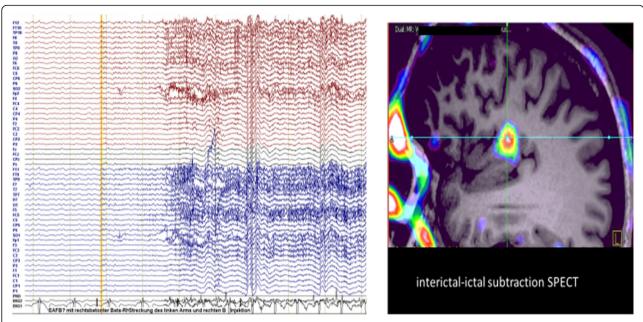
Left: Ictal EEG with muscle artifacts, tachycardia after seizure onset. Injection of technetium HMPAO 5 s after seizure onset for Single Photon Emission Computed Tomography (SPECT). Right: SPECT demonstrates ictal hyperperfusion in the sylvian region (courtesy Prof. T. Kuwert, University Hospital Erlangen)
